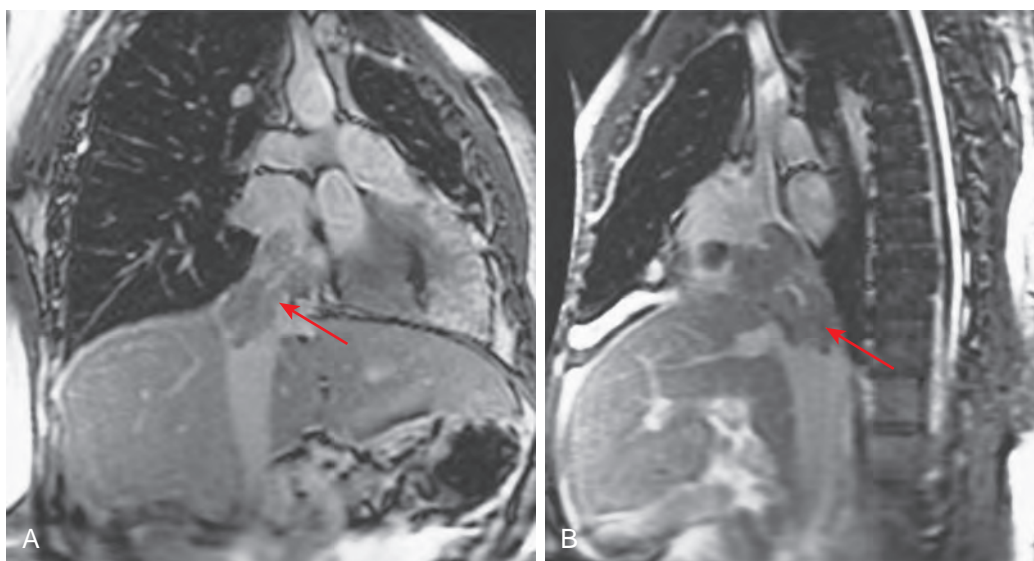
Budd-Chiari syndrome: MRI findings in a patient with hepatocellular carcinoma invading the hepatic veins and inferior vena cava. Coronal (A) and parasagittal (B) images shows tumor thrombus (arrows) invading the inferior vena cava and right atrium.
